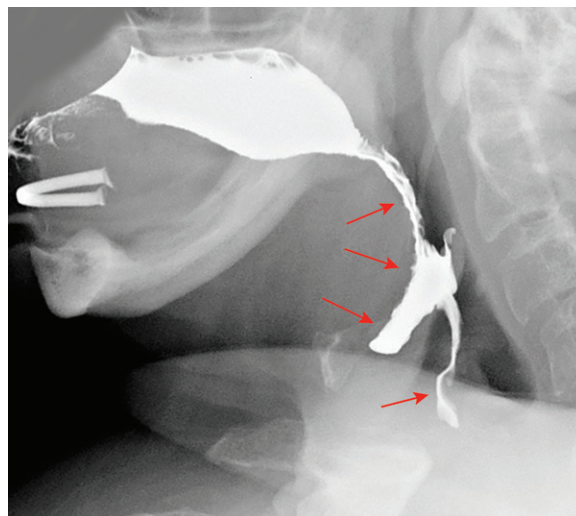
Leakage from the mouth into the pharynx in a 58-year-old woman. Lateral radiograph of the oral cavity and pharynx before swallowing shows contrast material leaking from the mouth bolus to the valleculae and hypopharynx (arrows) due to incompetence of the glossopalatal seal.
